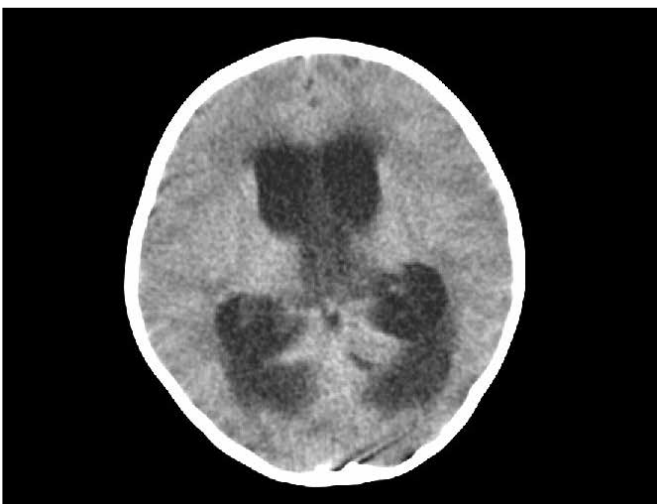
CT scan showed severe hydrocephalus after the patient's loss of consciousness.
